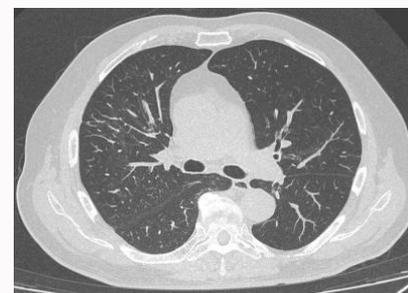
Chest CT after five months of pazopanib stopping: complete resolution of previous lung abnormalities. CT: Computed Tomography
